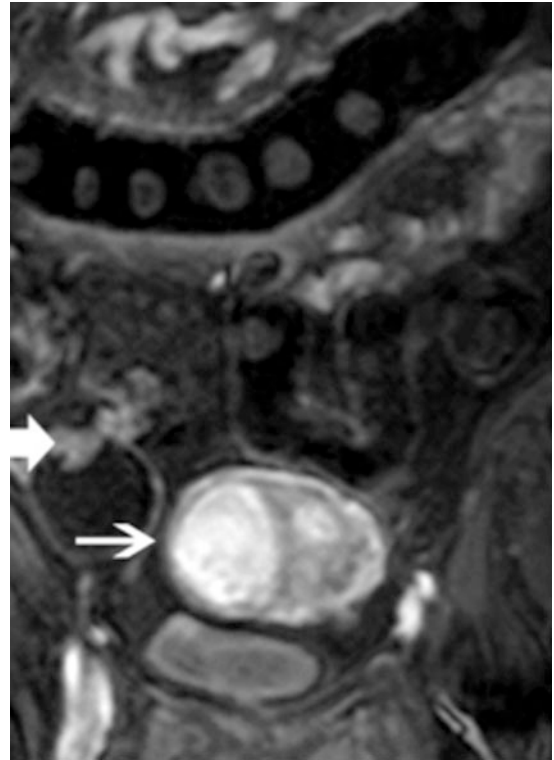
Dark lumen MRC: Coronal T1-weighted SPGR image post IV shows concerning enhancement with the mural nodule within a right adnexal mass (*block arrow*). The uterine lesion (*small arrow*) was shown to represent a leiomyoma (Courtesy of Sonia Rodríguez-Gomez, MD, Hospital Clínico, Barcelona, Spain)
